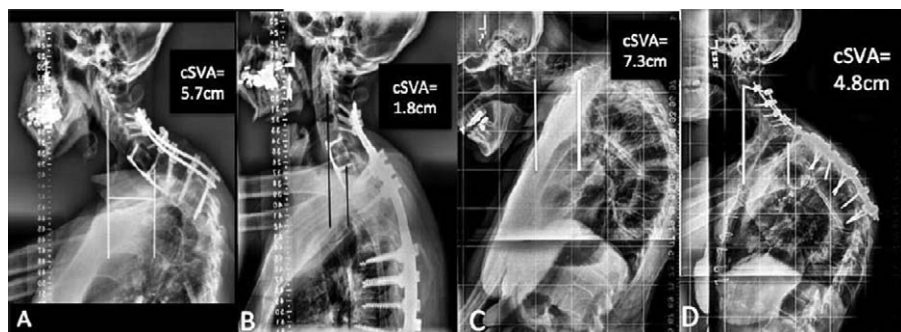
A, Preoperative radiographs of a patient with cervical deformity following a prior anterior/posterior cervical fusion surgery. B, 3-Month postoperative radiographs of the same patient who underwent a revision surgery consisting of a three-column osteotomy at T2 and fusion from C2-T9 with adequate restoration of cervical alignment. C, Preoperative radiographs of another patient with cervical deformity due to a large upper thoracic kyphosis and partially flexible dropped head syndrome. D, 3-Month postoperative radiographs of the same patient who underwent a three-column osteotomy at T2 and fusion from C2-T7 with the development of distal junctional kyphosis and suboptimal restoration of cervical alignment.
